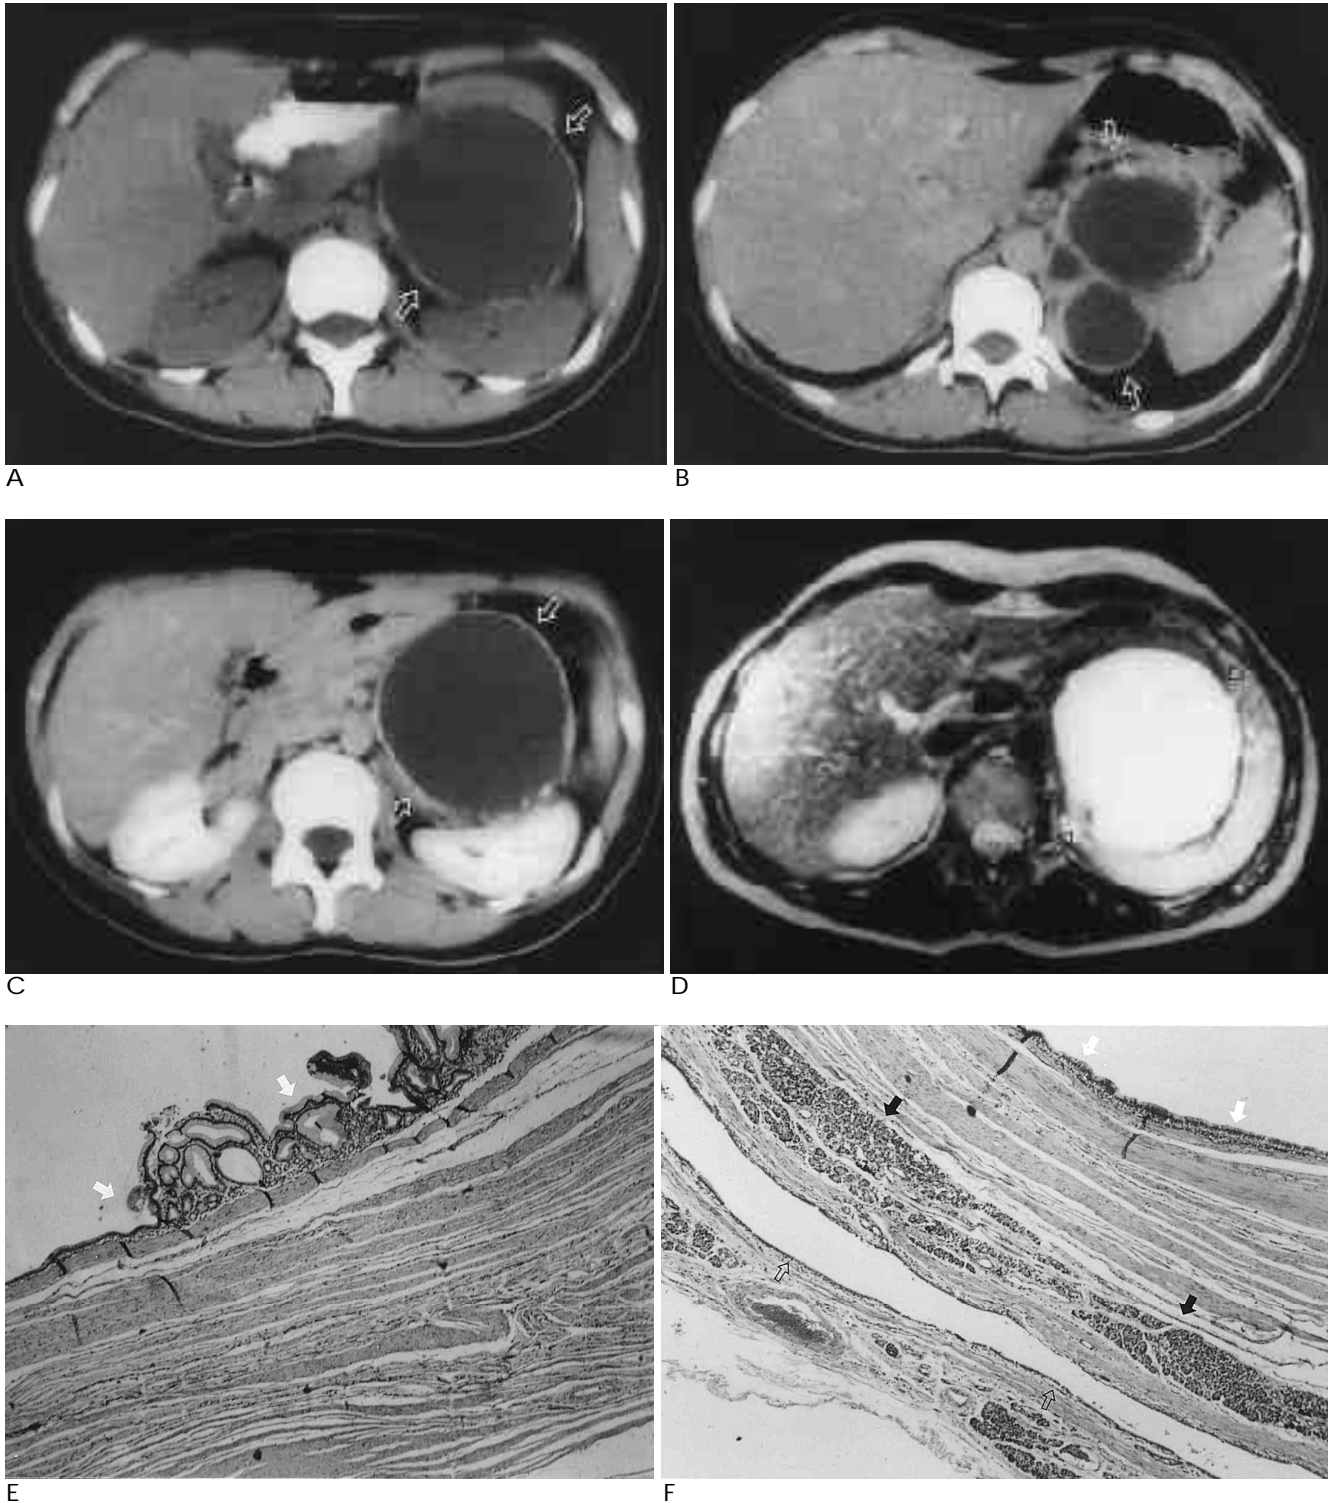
A. Precontrast CT scan shows well defined homogeneous low density mass with rim calcifications displacing pancreas anteriorly(arrows).
